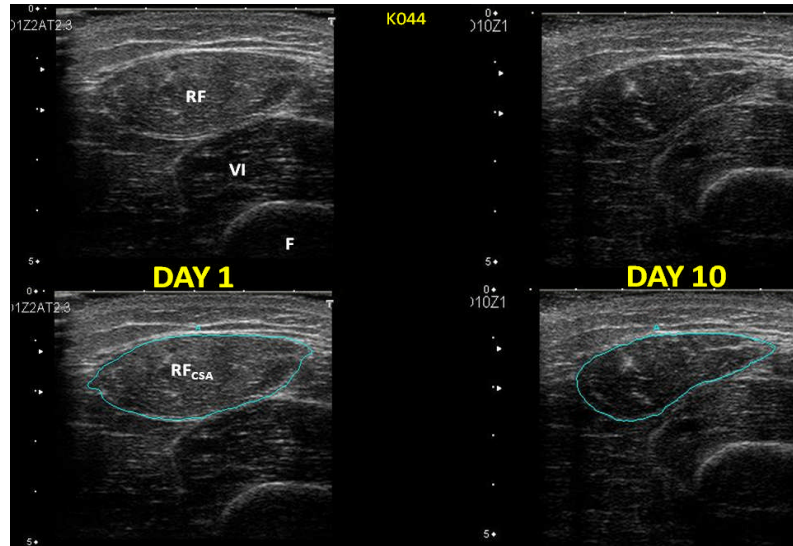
Ultrasound measurements of Rectus Femoris cross-sectional area ( $RF_{CSA}$ ) on day 1 (left panel) and day 10 (right panel) in a representative patient. From top left, anticlockwise: RF=Rectus Femoris, VL=Vastus Lateralis, F=Femur.
